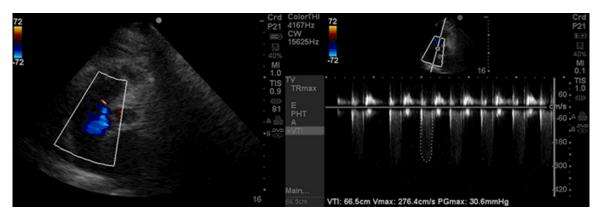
Echocardiogram (on admission) revealed mild enlargement in root of pulmonary artery and tricuspid regurgitation with pulmonary artery pressure about 38 mmHg.
